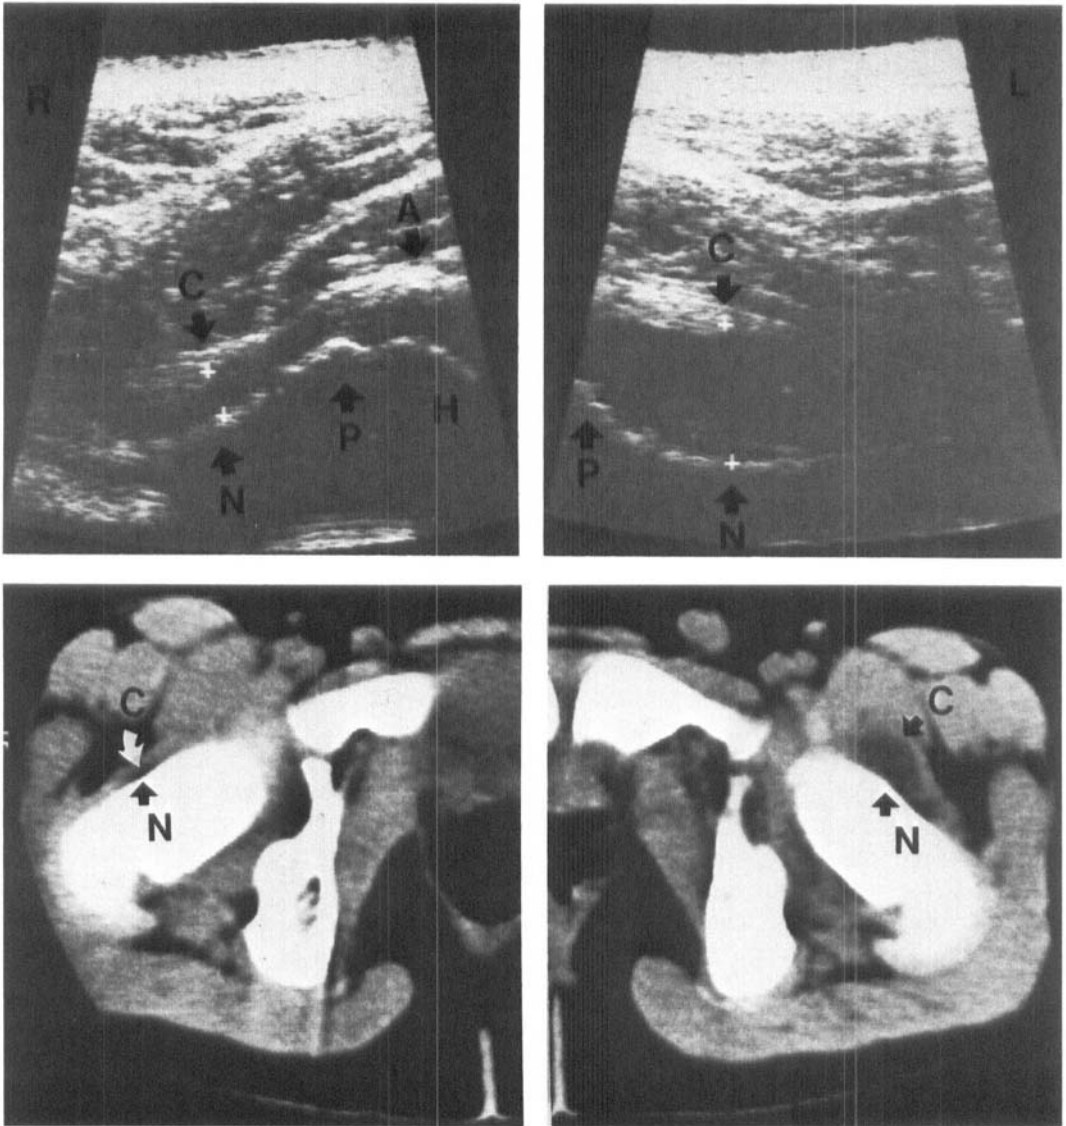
Ultrasonography (top) and CT (bottom) of the right normal (R) and left symptomatic (L) hips prior to aspiration. The following anatomical structures are identified on the normal right side: acetabular labrum (A), head of femur (H), growth plate (P), neck of femur (N) and joint capsule (C). On the left side, the capsule is distended 10 mm ventrally due to an effusion.
